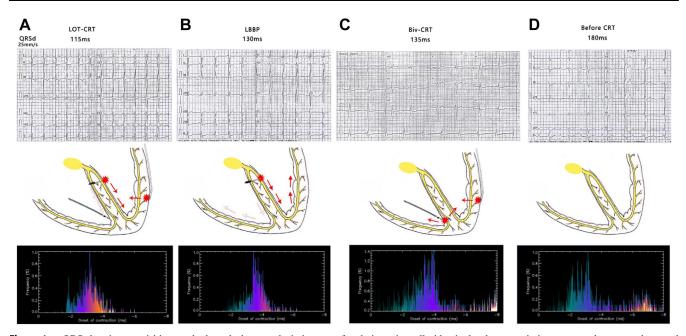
QRS duration acquisition methods and phase analysis images of cadmium-zinc-telluride single photon emission computed tomography gated myocardial perfusion imaging.
